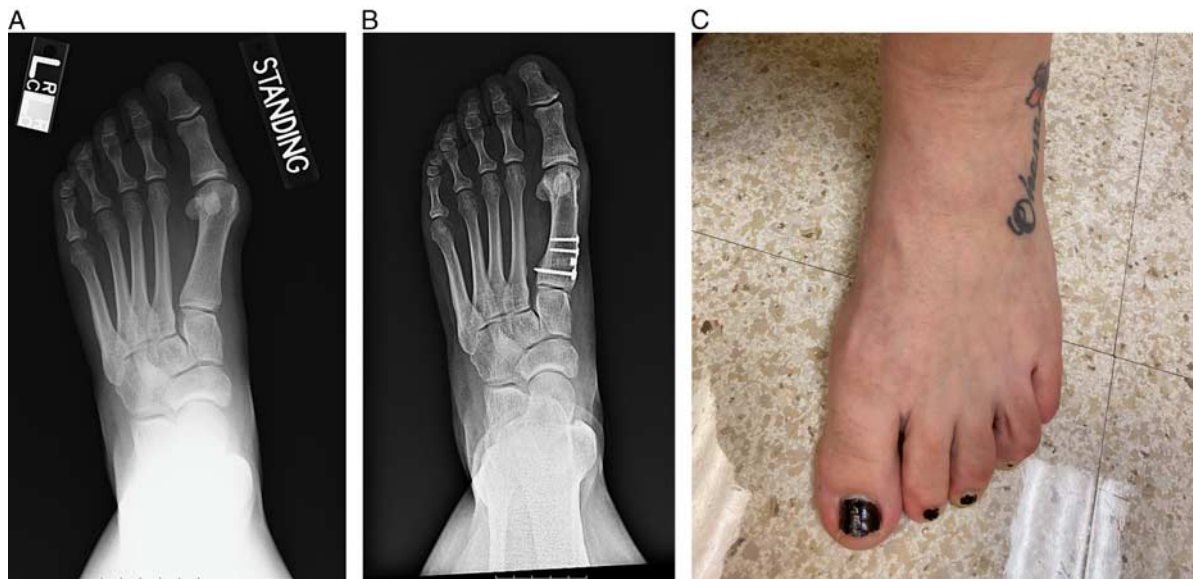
Ten-year follow-up of proximal opening wedge osteotomy without a distal biplanar chevron osteotomy. Although adding the distal osteotomy would likely have prevented some of the recurrences we are seeing, this patient remains very happy with her long-term outcome. A, Preoperative anteroposterior radiograph demonstrating 31 degrees hallux valgus angle and 15.5 degrees intermetatarsal angle. B, Ten-year follow-up anteroposterior radiograph showing slight recurrence and loss of hallux valgus angle now measuring 18.5 and 6.9 degrees intermetatarsal angle. C, Ten-year clinical follow-up image.
